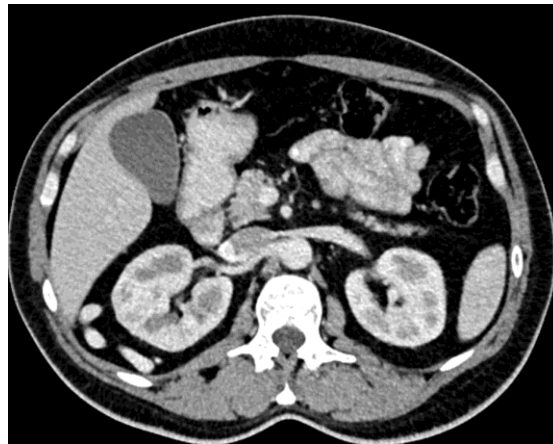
Axial portal-venous phase CT confirming absence of a right renal vein entering the IVC.
